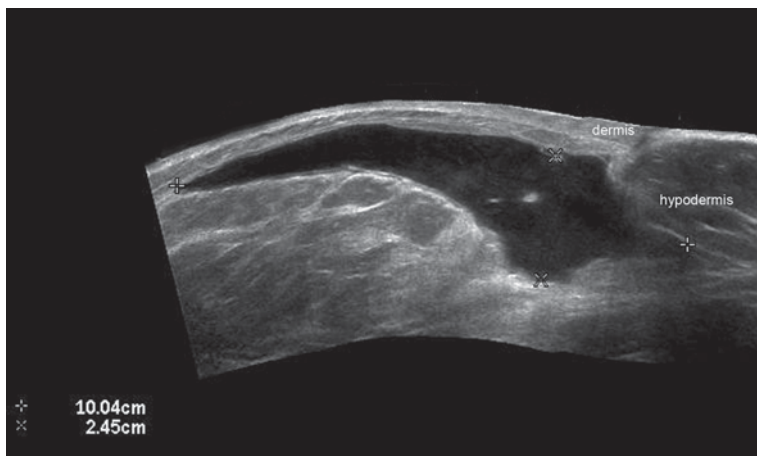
Abscess. Ultrasound (gray scale, *transverse* view, inframammary region) shows 10.4 cm transverse \times 2.5 cm depth, anechoic fluid hypodermal collection (*between* markers) with some hyperechoic echoes due to debris
